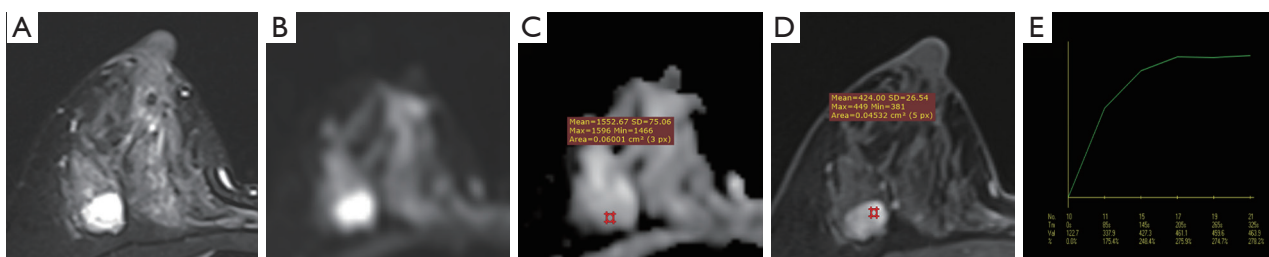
Breast MRI in FA female patient, aged 37 years old. (A) T2-dynamic sequence shows a circular mass in the upper outer quadrant of the right breast, with uniform high signal intensity and smooth edges. (B) The DWI image shows a high signal intensity in the mass. (C) The ADC image using a 0.06 cm² circular ROI shows high signal intensity of the tumor, with an average ADC value of approximately 1.552×10⁻³ mm²/s. (D) Enhanced image display with uniform high signal. (E) TIC shows an inflow type (type I). MRI, magnetic resonance imaging; FA, fibroadenoma; DWI, diffusion-weighted imaging; ADC, apparent diffusion coefficient; ROI, region of interest; TIC, time-signal intensity curve.
